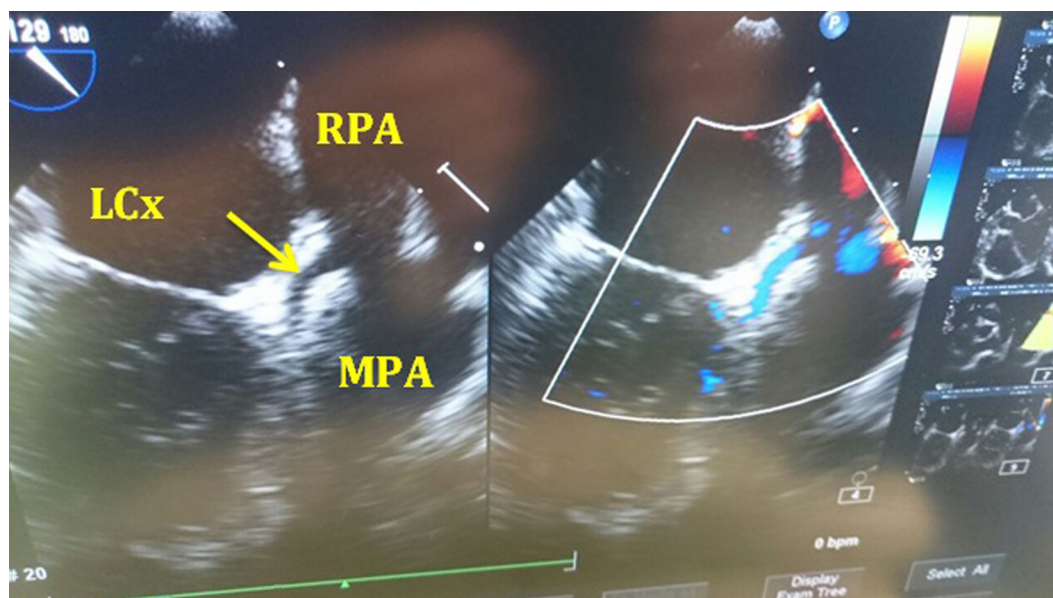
Transoesophageal echocardiography showed main pulmonary artery (MPA), right pulmonary artery (RPA), and left circumflex coronary artery (LCx).
